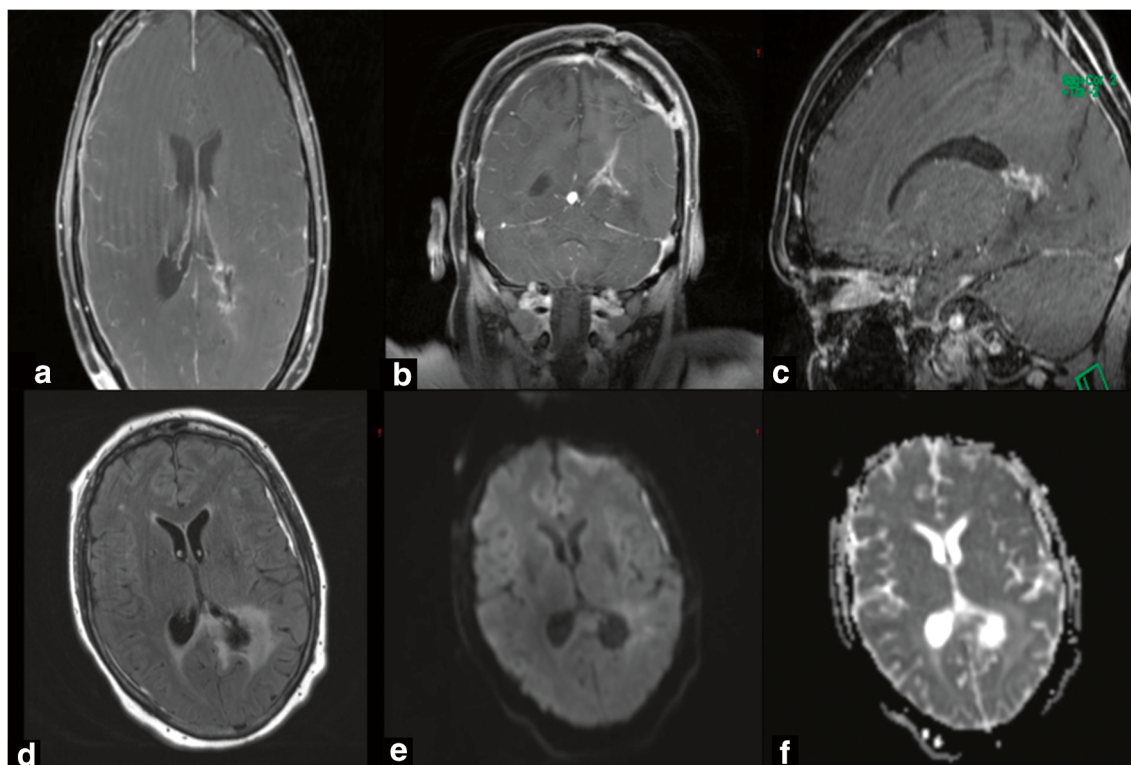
The axial (a), coronal (b), and sagittal (c) contrast-enhanced, postoperative MRI revealed a complete tumor resection. Minimal
